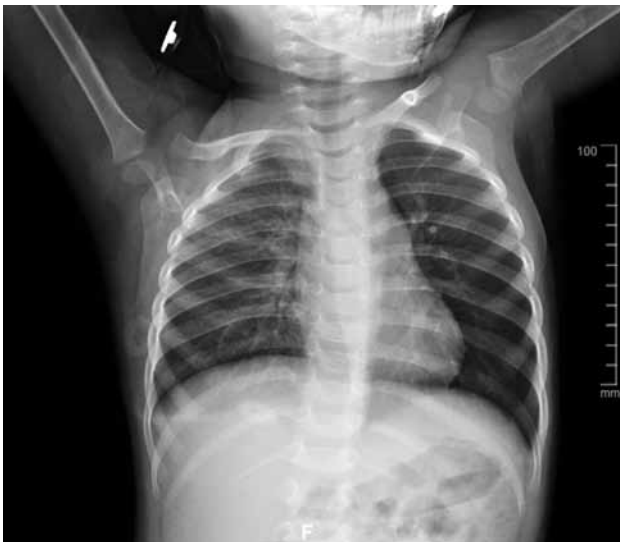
Chest X-ray showing hyperinflation on left side.
